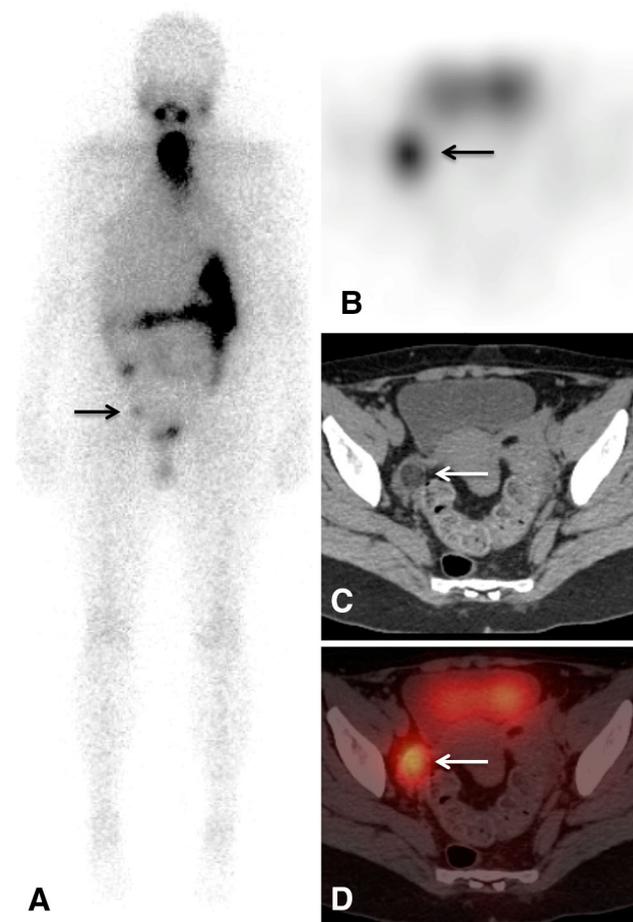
Benign mimic of distant metastases found in a 48-year-old woman post-total thyroidectomy for papillary thyroid cancer. Post-therapy scan obtained several days after 100 mCi I-131. Anterior planar image (a) demonstrates focal uptake in the right side of the pelvis that was not present on the diagnostic scan (arrow). Axial SPECT (b) confirms the presence of focal activity in the right pelvis (arrow). Axial unenhanced CT (c) and fused SPET-CT (d) localize the activity to a benign cystic teratoma (dermoid) of the right ovary (arrows). SPET-CT accurately characterized this lesion as benign mimic of malignancy and avoided the misdiagnosis of distant metastases (color figure online)
